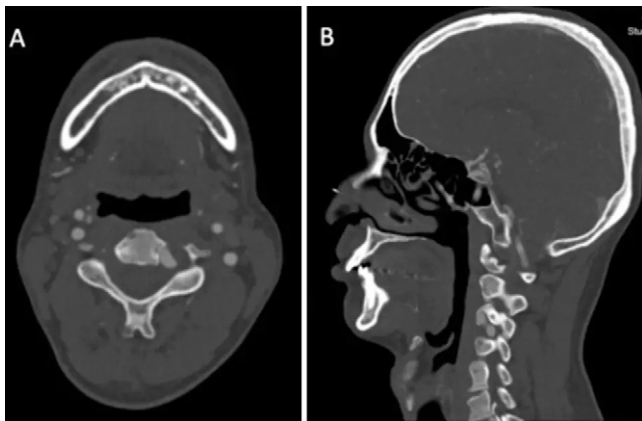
Preoperative axial (A) and sagittal (B) CT angiography sequences showing a left vertebral artery loop occupying an enlarged left C3–4 neuroforamen.
